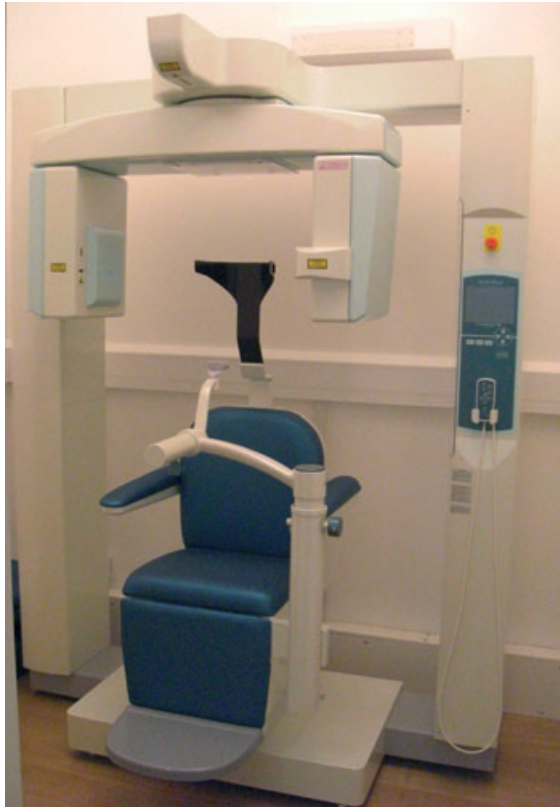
A typical cone beam computed tomography scanner (3D Accuitomo 80, J Morita, Kyoto, Japan), the overall footprint in similar to that of a panoramic machine making it ideal for dental practice.
